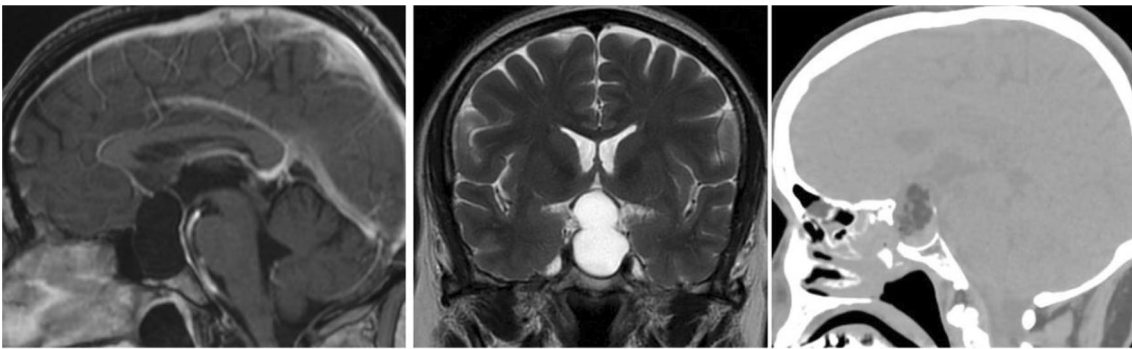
Preoperative MRI scan and Day one postoperative CT scan
